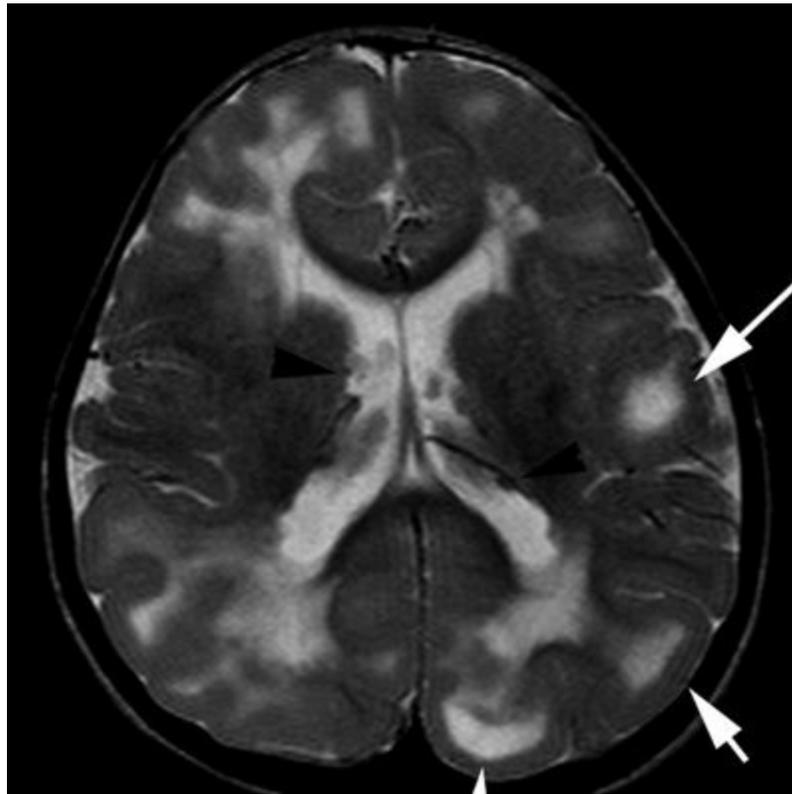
Tuberous sclerosis. Axial T2-weighted image from MRI without gadolinium in a 9-year-old male with over 20 seizures per day shows multiple subependymal low-signal-intensity nodules (black arrowheads) and multiple bilateral malformations of cortical development characterized by gyral broadening and subcortical white matter hyperintensity (white arrows).
